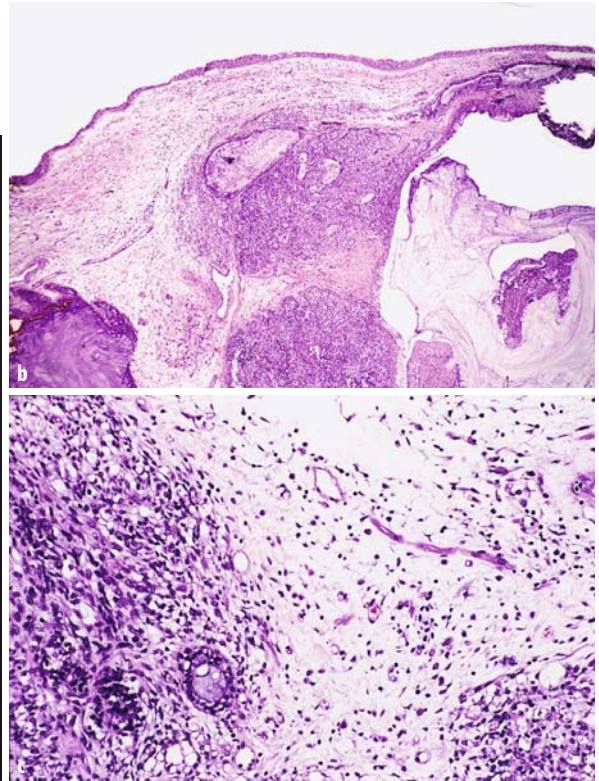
Teratocarcinosarcoma. a CT scan showing massive destructive infiltration of the nasal cavity and maxillary sinus on the left. With permission [75] b Cystic spaces filled with mucin are partly covered by benign columnar epithelium and surrounded by
